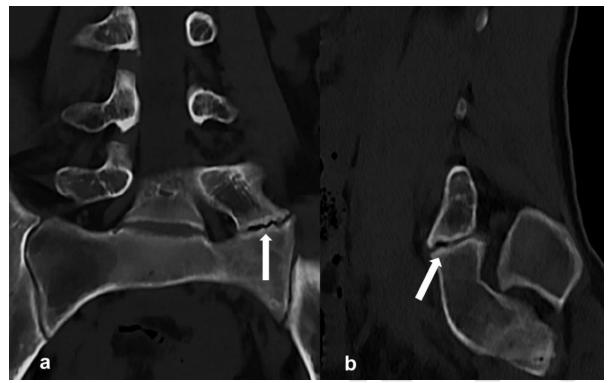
A 20-year-old female patient with Castellvi Type II shows irregularities in the bony surfaces, subchondral sclerosis, and degenerative vacuum phenomena in the joint space at the left pseudoarticulation level (arrows). No signs of degeneration have yet been observed at other levels. Coronal (a) and sagittal CT image (b)
